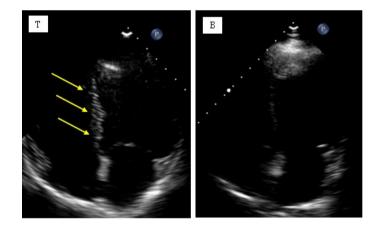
The echocardiographic scar (eSCAR) sign as detected by pulse cancellation imaging.
